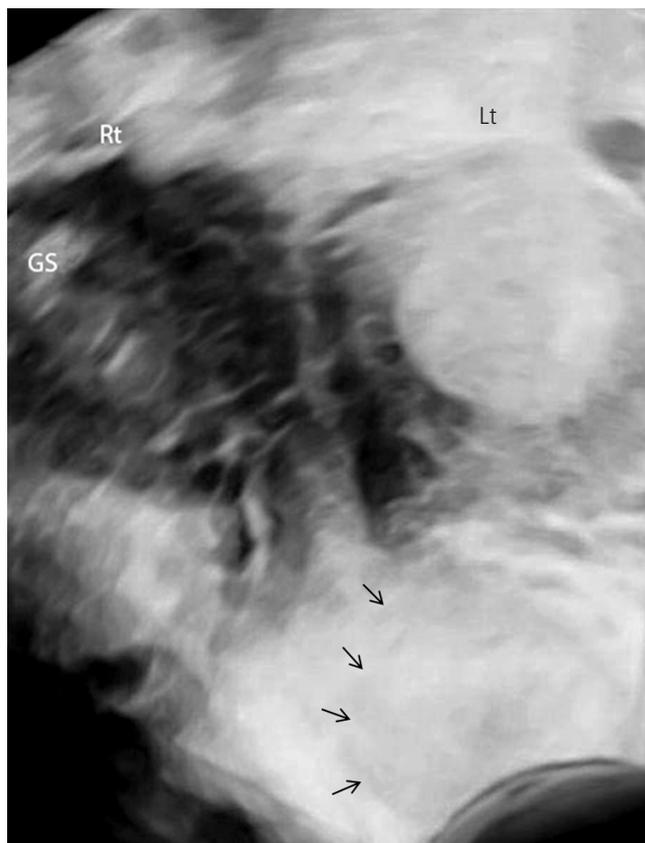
Three-dimensional ultrasonographic image of septate uterus with hemioctobered vagina. The gestational sac (GS) is seen in the right (Rt) uterus and the left (Lt) obstructed vagina (black arrows) is bulging into the Rt vagina.
